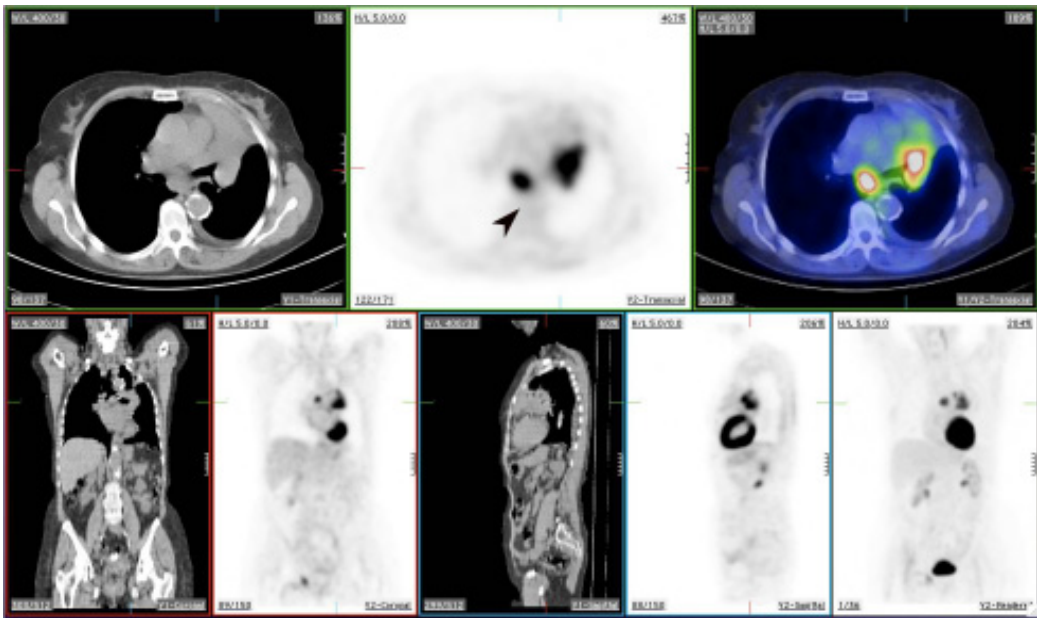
PET/CT for staging in a patient with non-small cell lung carcinoma, where a subcarinal node (arrow) was identified on PET/CT.
